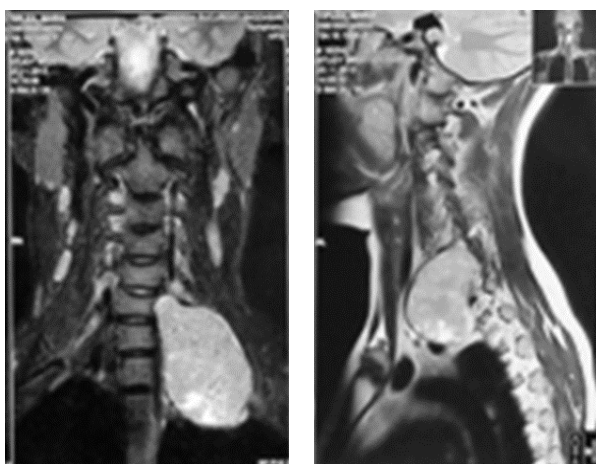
Gadolinium-enhanced cervical MRI, coronal and sagittal section, showing a large extramedullary spinal tumor at the level of C6-C7 vertebrae.
